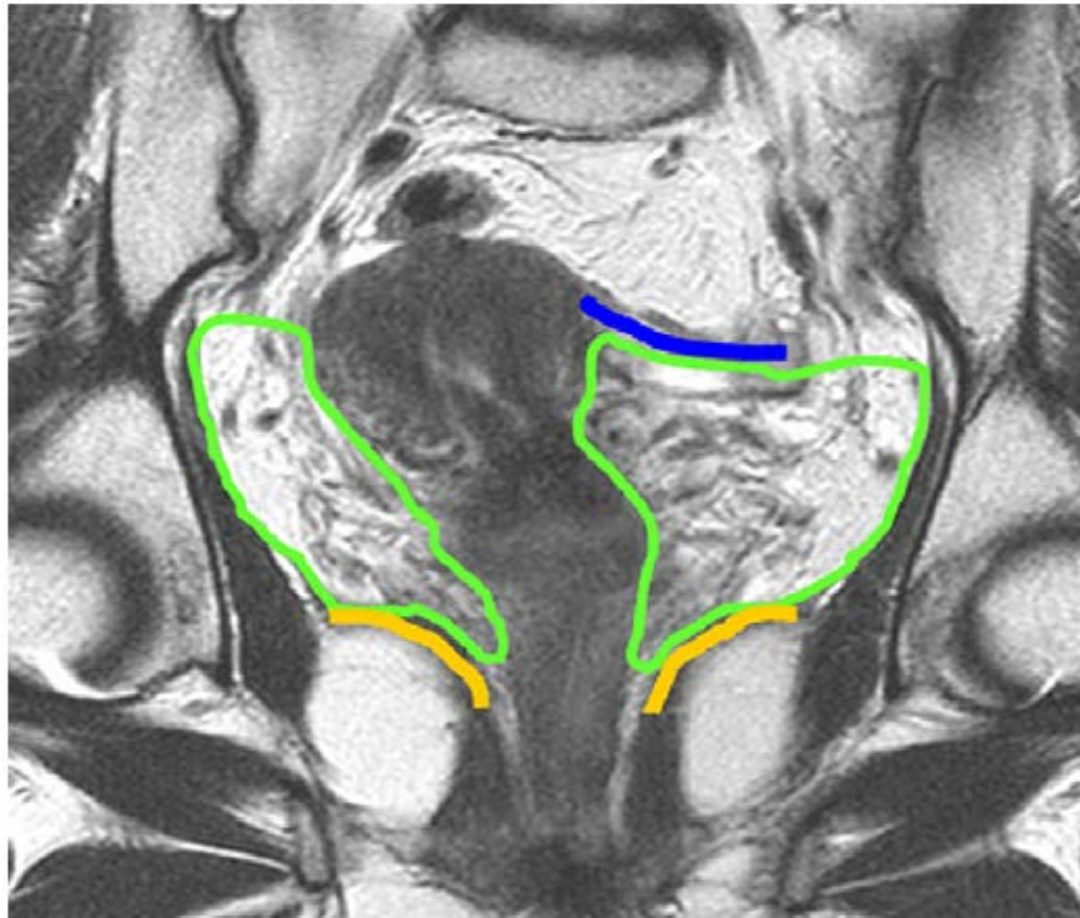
Coronal T<sub>2</sub>-weighted MR image of a patient with a relatively upright uterus, demonstrating the superior and inferior boundaries of parametria. Top of broad ligament (blue), pelvic diaphragm (yellow), parametria (green).
